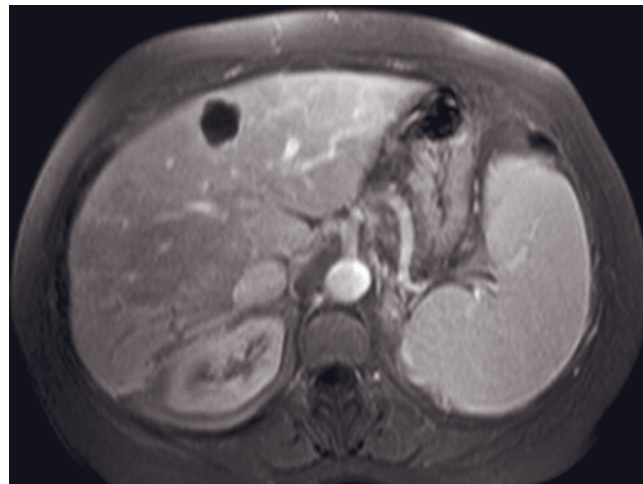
Foregut cysts. Coronal T2-weighted SS-ETSE (*a*), transverse SGE (*b*), and 90-s fat-suppressed postgadolinium SGE (*c*) images. A 3-cm cystic lesion is noted superiorly on the border between medial and lateral segments. The lesion extends beyond the contour of the liver and has a thin perceptible wall, features that are characteristic of foregut cysts.
